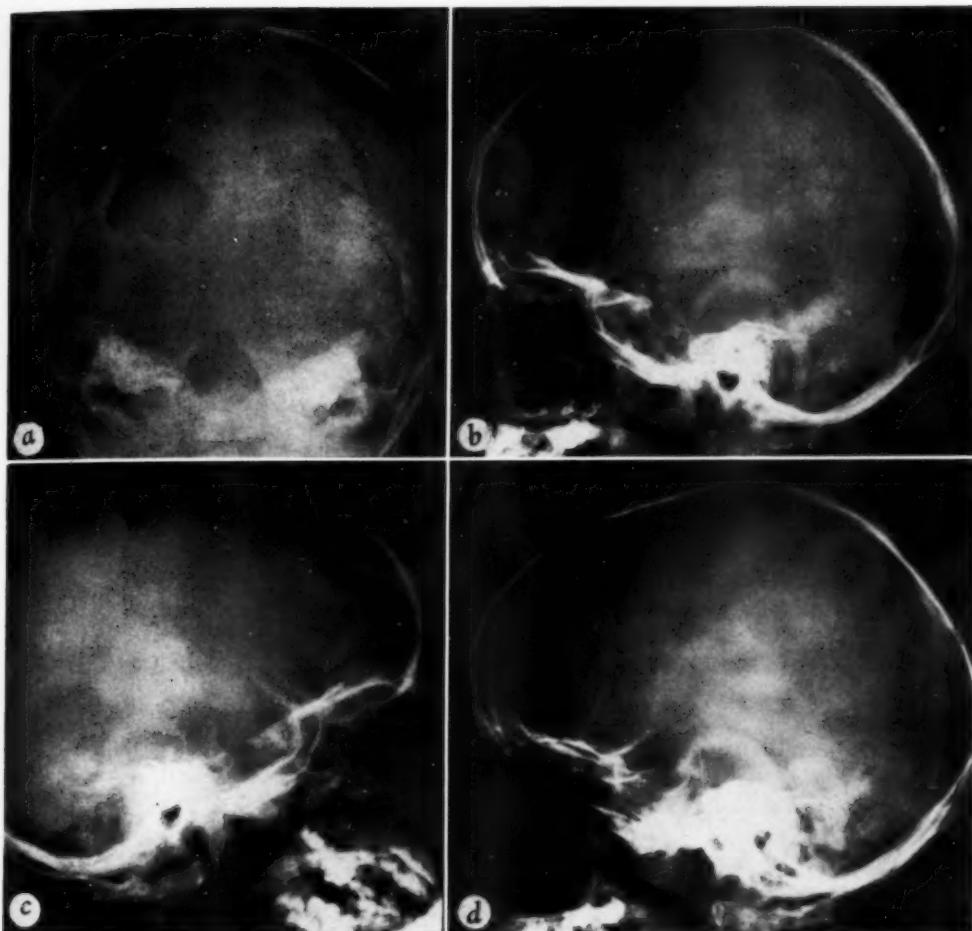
Case 9. Anteroposterior (a) and lateral (b) roentgenograms of skull made in June 1946, before treatment, giving evidence of large defect in occipital bone. Lateral roentgenograms of skull, (c) at onset of diabetes insipidus in 1947; (d) in 1950.
